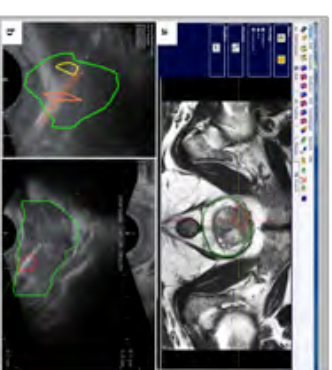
a) Bioler® software for contouring of the prostate and the target lesion. b) MRI/TRUS-fusion and -biopsy.
